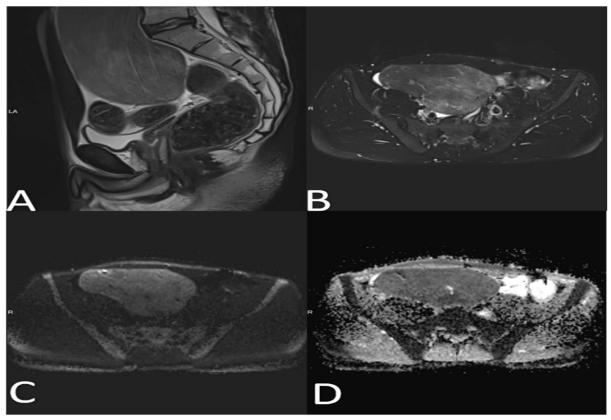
MRI Findings: A: Sagittal plane T2 weighted series B: T2 transverse plane C,D: Diffusion MRI images.
